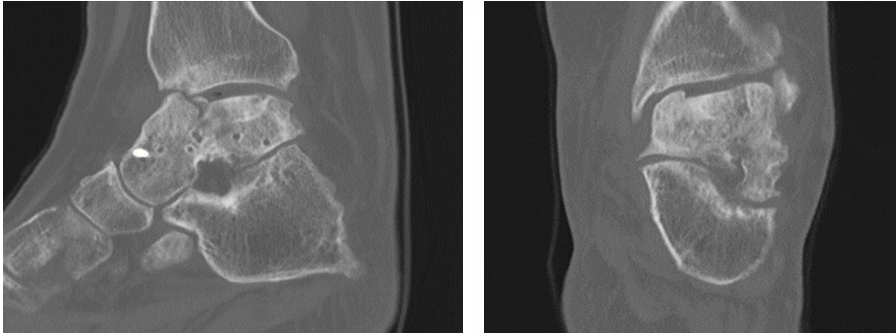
Pre-operative CT scans provide further information and suggest that the head and neck of the talus remain viable thus making this a case of partial AVN of the talus
